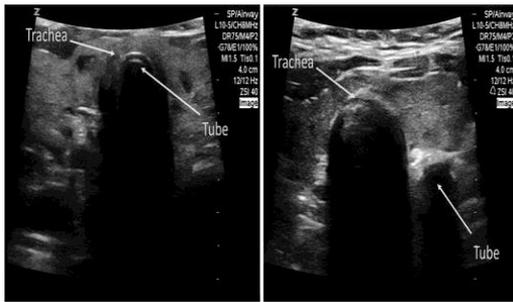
Ultrasound images of endotracheal and esophageal intubations. On the (left) image, a normal endotracheal intubation is shown with the echogenic semicircular tube visible within the lumen of the trachea. On the (right) one, an esophageal intubation can be identified by the presence of a 'double tract sign' with a second semi-circular acoustic shadow appearing outside of the trachea
